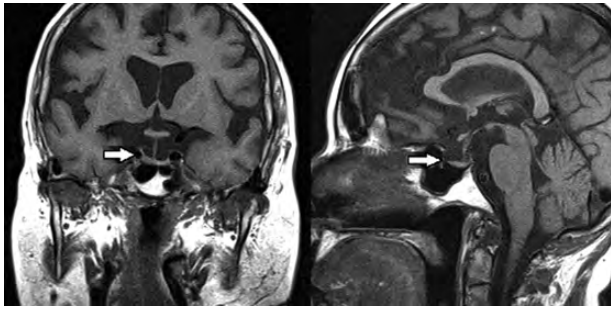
Coronal and sagittal views of T1-weighted MR image of the brain.
